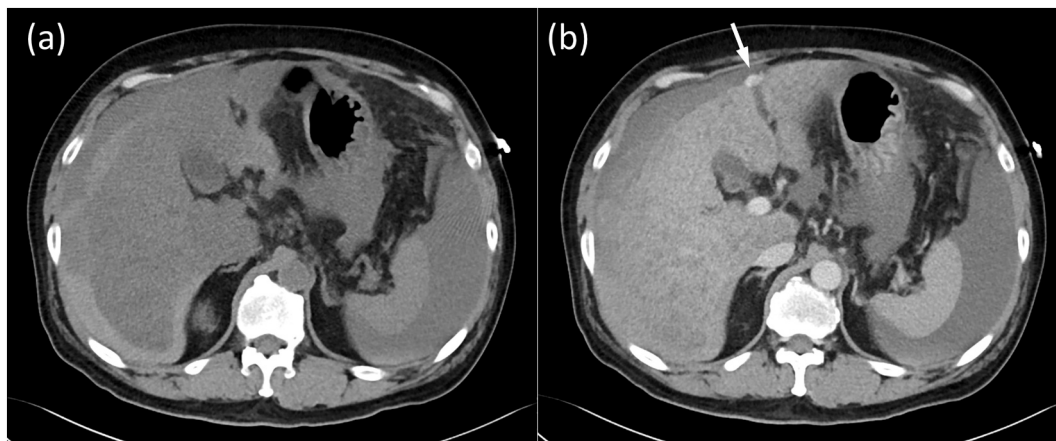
Computed tomography (CT) images showing a large amount of high-density bloody ascites (a). The liver is atrophied, with an irregular surface. In an enhanced view (b), there are no space-occupying lesions, such as hepatocellular carcinoma, in the liver and no aneurysm or other sources of bleeding confirmed preoperatively. Careful retrospective observation reveals a slight leakage of contrast agents near the expanded umbilical vein (arrow).
